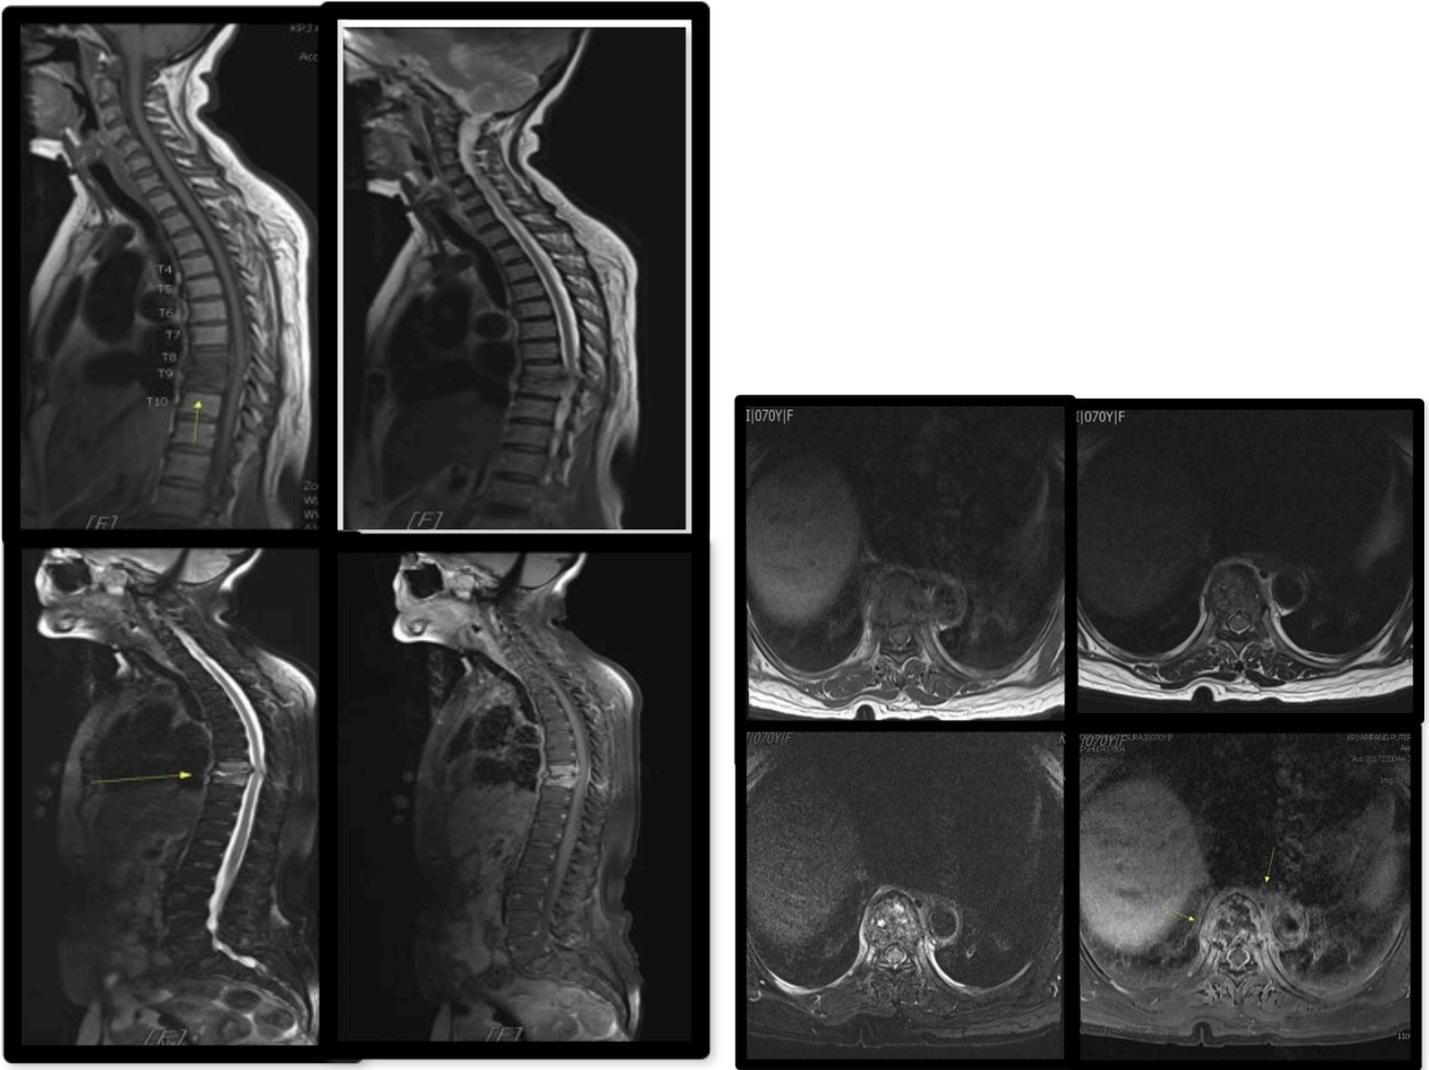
MRI films of spine at 2 months follow up, suggestive of spondylodiscitis of T8&T9 with suspicion of tuberculosis infection.
